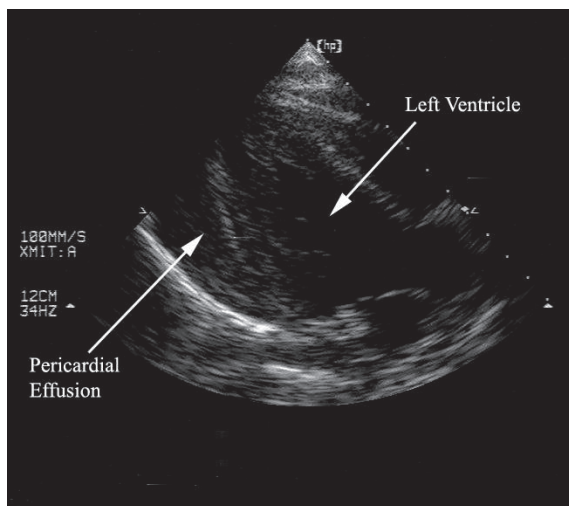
Bedside echocardiogram shows a large pericardial effusion.
